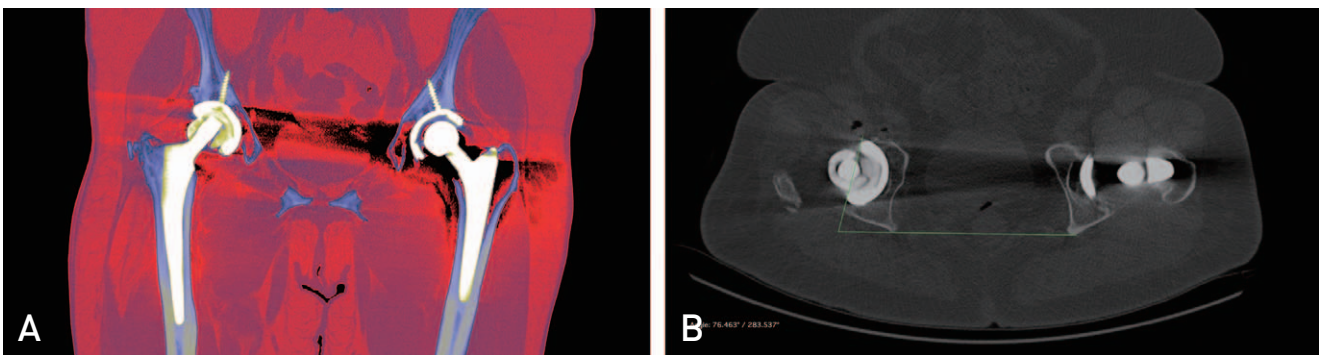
Computed tomographic evaluation reveals fragmentation in the ceramic head (A). Acetabular cup anteversion was measured as 14° (B).
